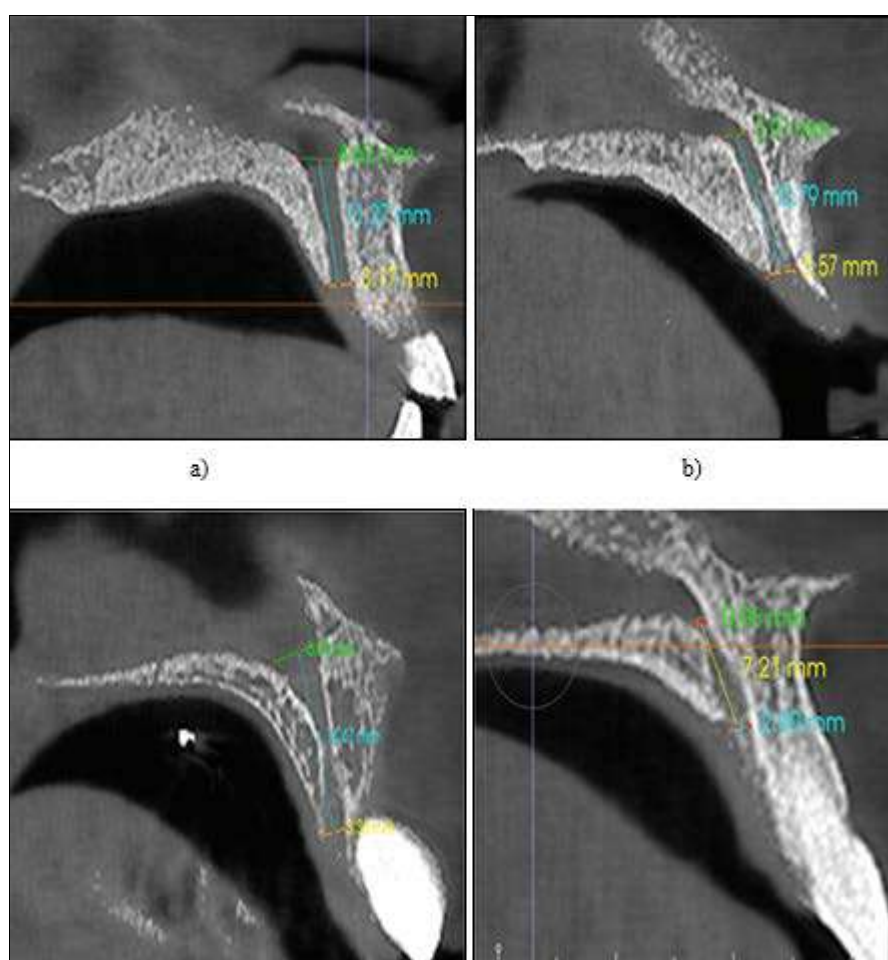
Cone-beam computed tomography images show the four shapes of the nasopalatine canal on sagittal planes. (a) Cylindrical shape, (b) funnel shape (c) hourglass shape (d) spindle shape
